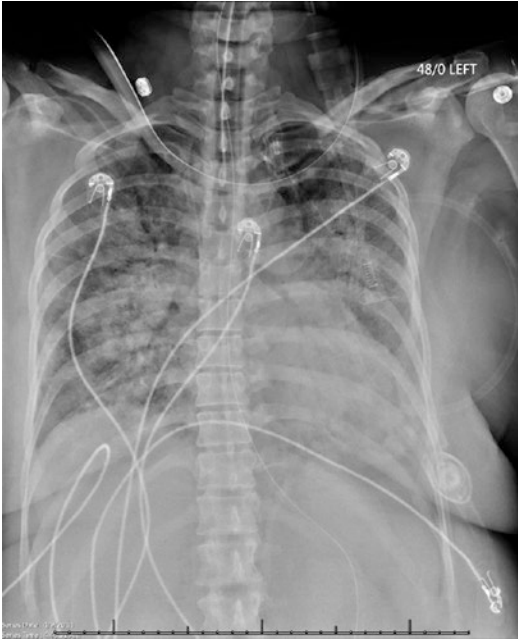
Chest x-ray of patient with ARDS from case study showing bilateral alveolar infiltrates
